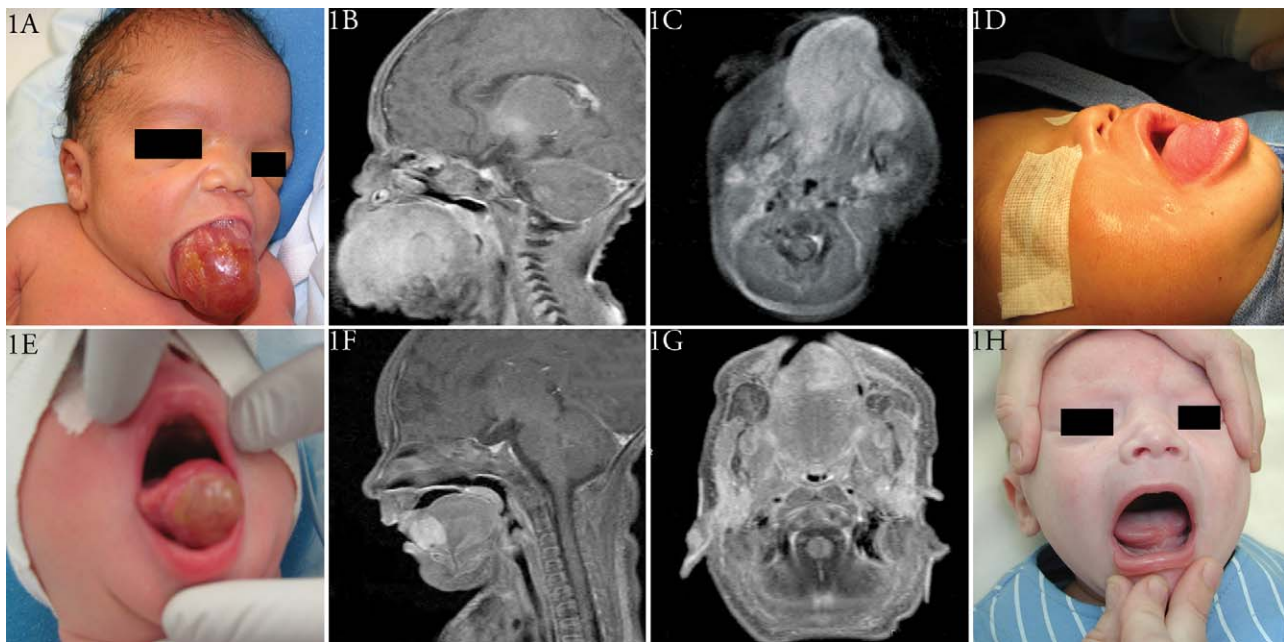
(A) Case 1 spindle cell rhabdomyosarcoma, clinical pre-operative photo. (B) Case 1 T1-weighted post-contrast MRI, sagittal view. (C) Case 1 MRI, axial view. (D) Case 1, clinical photo after several surgical debulking procedures and chemotherapy. (E) Case 2 fibromatosis, clinical pre-operative photo. (F) Case 2 T1-weighted post-contrast MRI, sagittal view. (G) Case 2 MRI, axial view. (H) Case 2, clinical photo after complete surgical resection.
